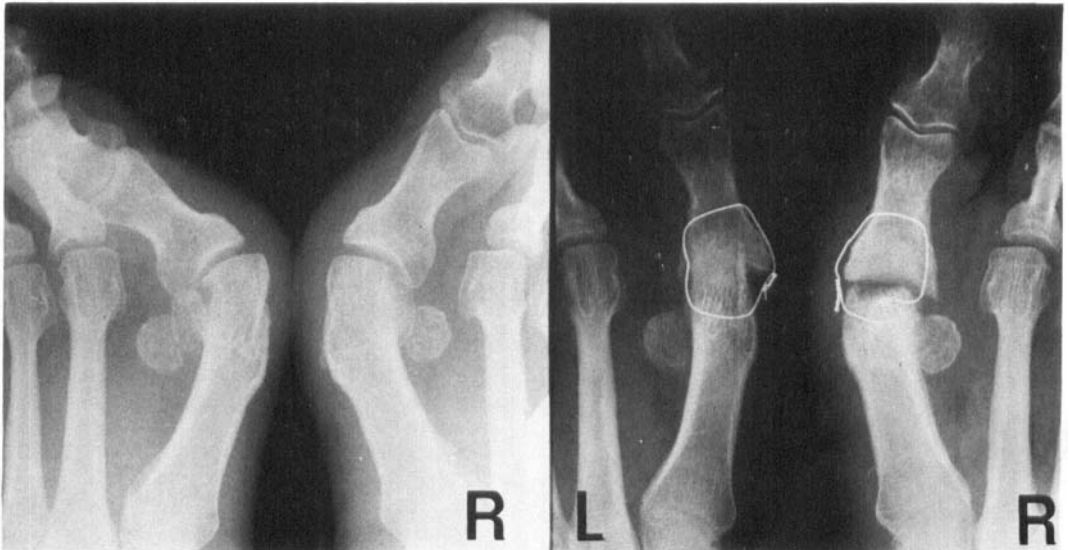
Radiographs showing a stress fracture through the base of the right cone in a patient who had previously undergone bilateral exostectomies. A. Before arthrodesis. B. 2 years after bilateral cone arthrodesis. The left side has united.
